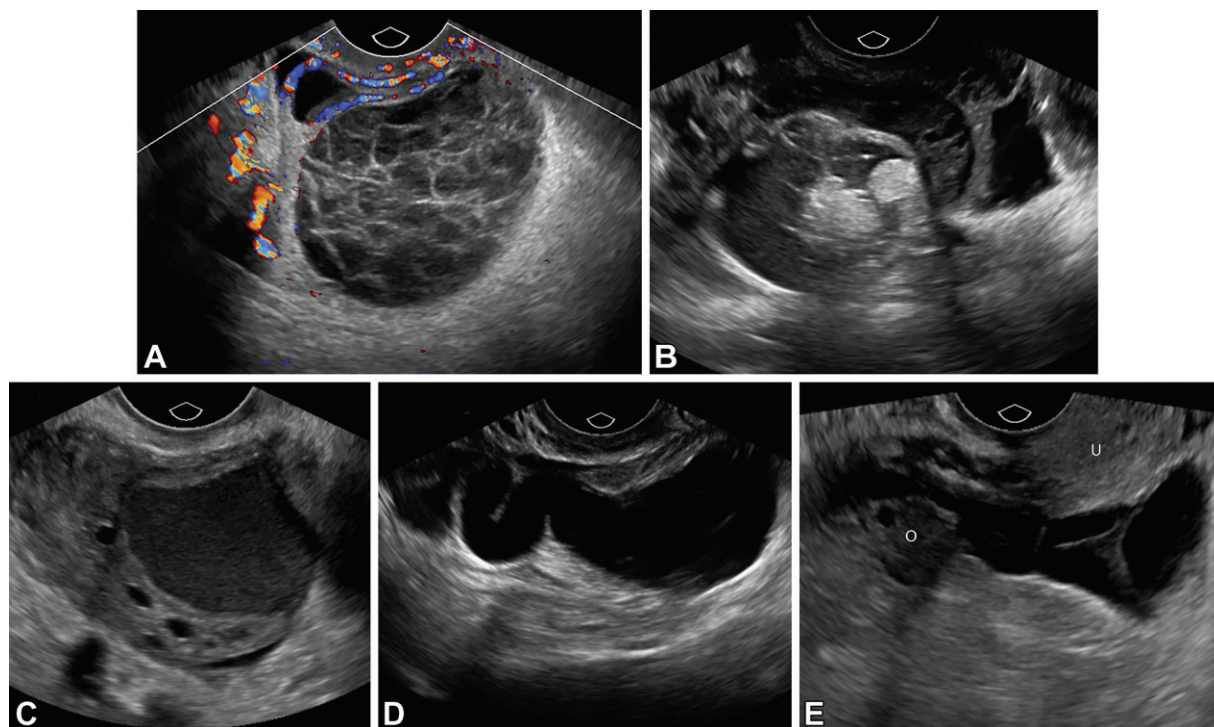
Examples of benign adnexal lesions with characteristic sonographic appearances (O-RADS 2). (A) Color Doppler US image in a premenopausal woman shows a 4.8-cm hemorrhagic cyst containing lacy reticular echoes and no internal vascularity. (B) US image in a premenopausal woman shows a 4.1-cm ovarian dermoid containing echogenic nodules and linear echoes representing hair. (C) US image in a premenopausal woman shows a 3.3-cm endometrioma, which contains diffuse fine low-level echoes and has a ground-glass appearance. (D) US image of a hydrosalpinx in a premenopausal woman shows a tubular simple fluid-filled structure with an “incomplete septa” sign separate from the adjacent ovary (not shown). (E) US image of a peritoneal inclusion cyst in a premenopausal woman shows a cystic mass abutting the ovary (O) and separate from the uterus (U). Other than thin bright reticular echoes, which are adhesions, the fluid is anechoic and conforms to the peritoneal space.
